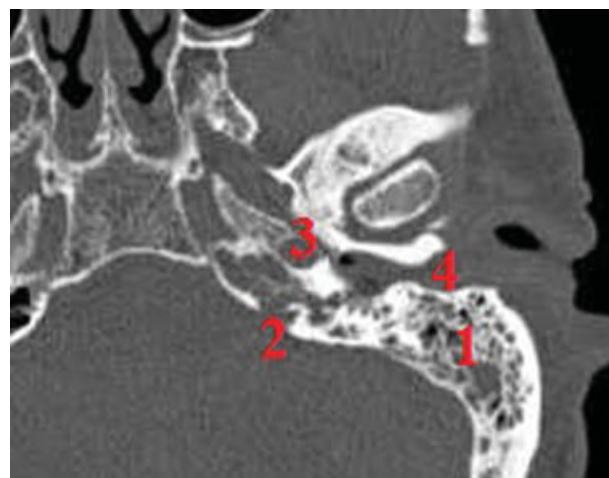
Computed tomography of the left petrous bone. 1, mastoid aircells; 2, Hyrtl fissure; 3, carotid foramen; 4, meatus acusticus externus.
